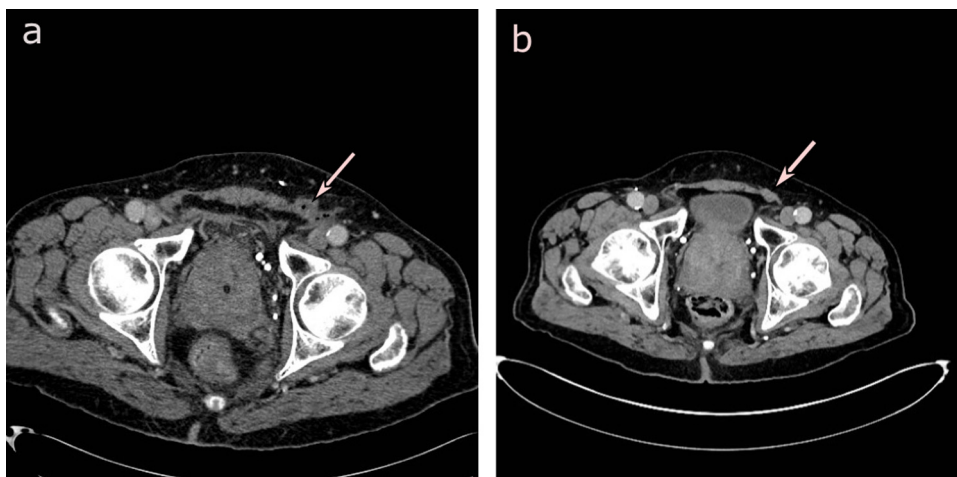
(a) Preoperative CT angiography showing a dilated left inguinal canal containing haematoma/blood without evidence for an incarcerated inguinoscrotal hernia (arrow). (b) Postoperative CT angiography showing an intact inguinal canal (arrow).
